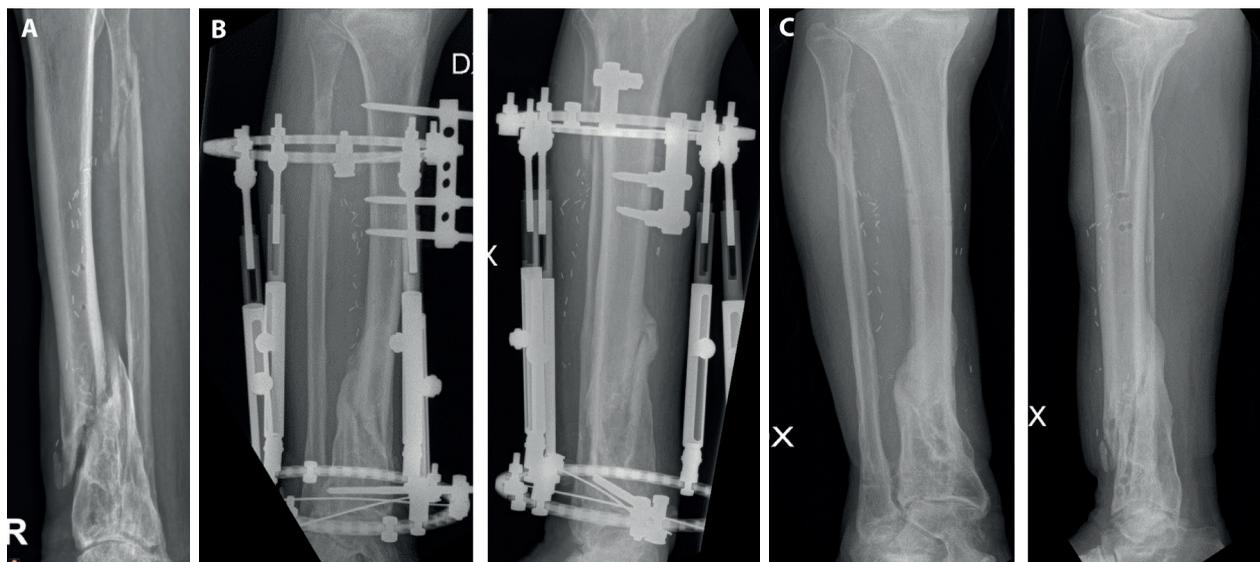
Case of distal tibia delayed union in patient initially treated conservatively (A). Patient underwent treatment with external fixator and percutaneous injection of BMAC: post-operative control (B). Fracture healed radiographically and clinically at 4 months (C).
